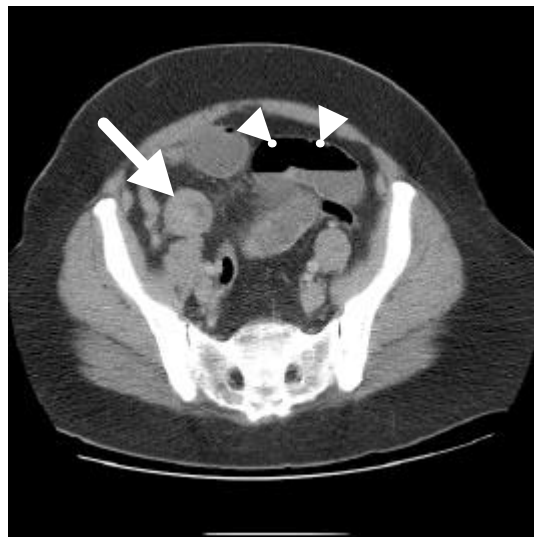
Computed tomography scan of the abdomen showing the site of the intussusception (white arrow), with dilated small bowel proximally (arrowheads)
